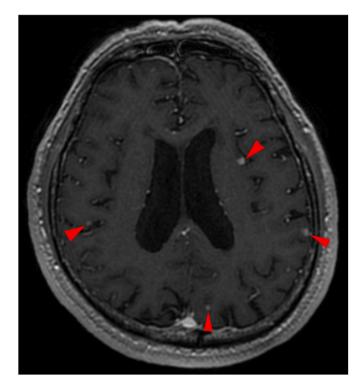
Brain magnetic resonance imaging reveals small multiple brain metastases (arrowheads).
